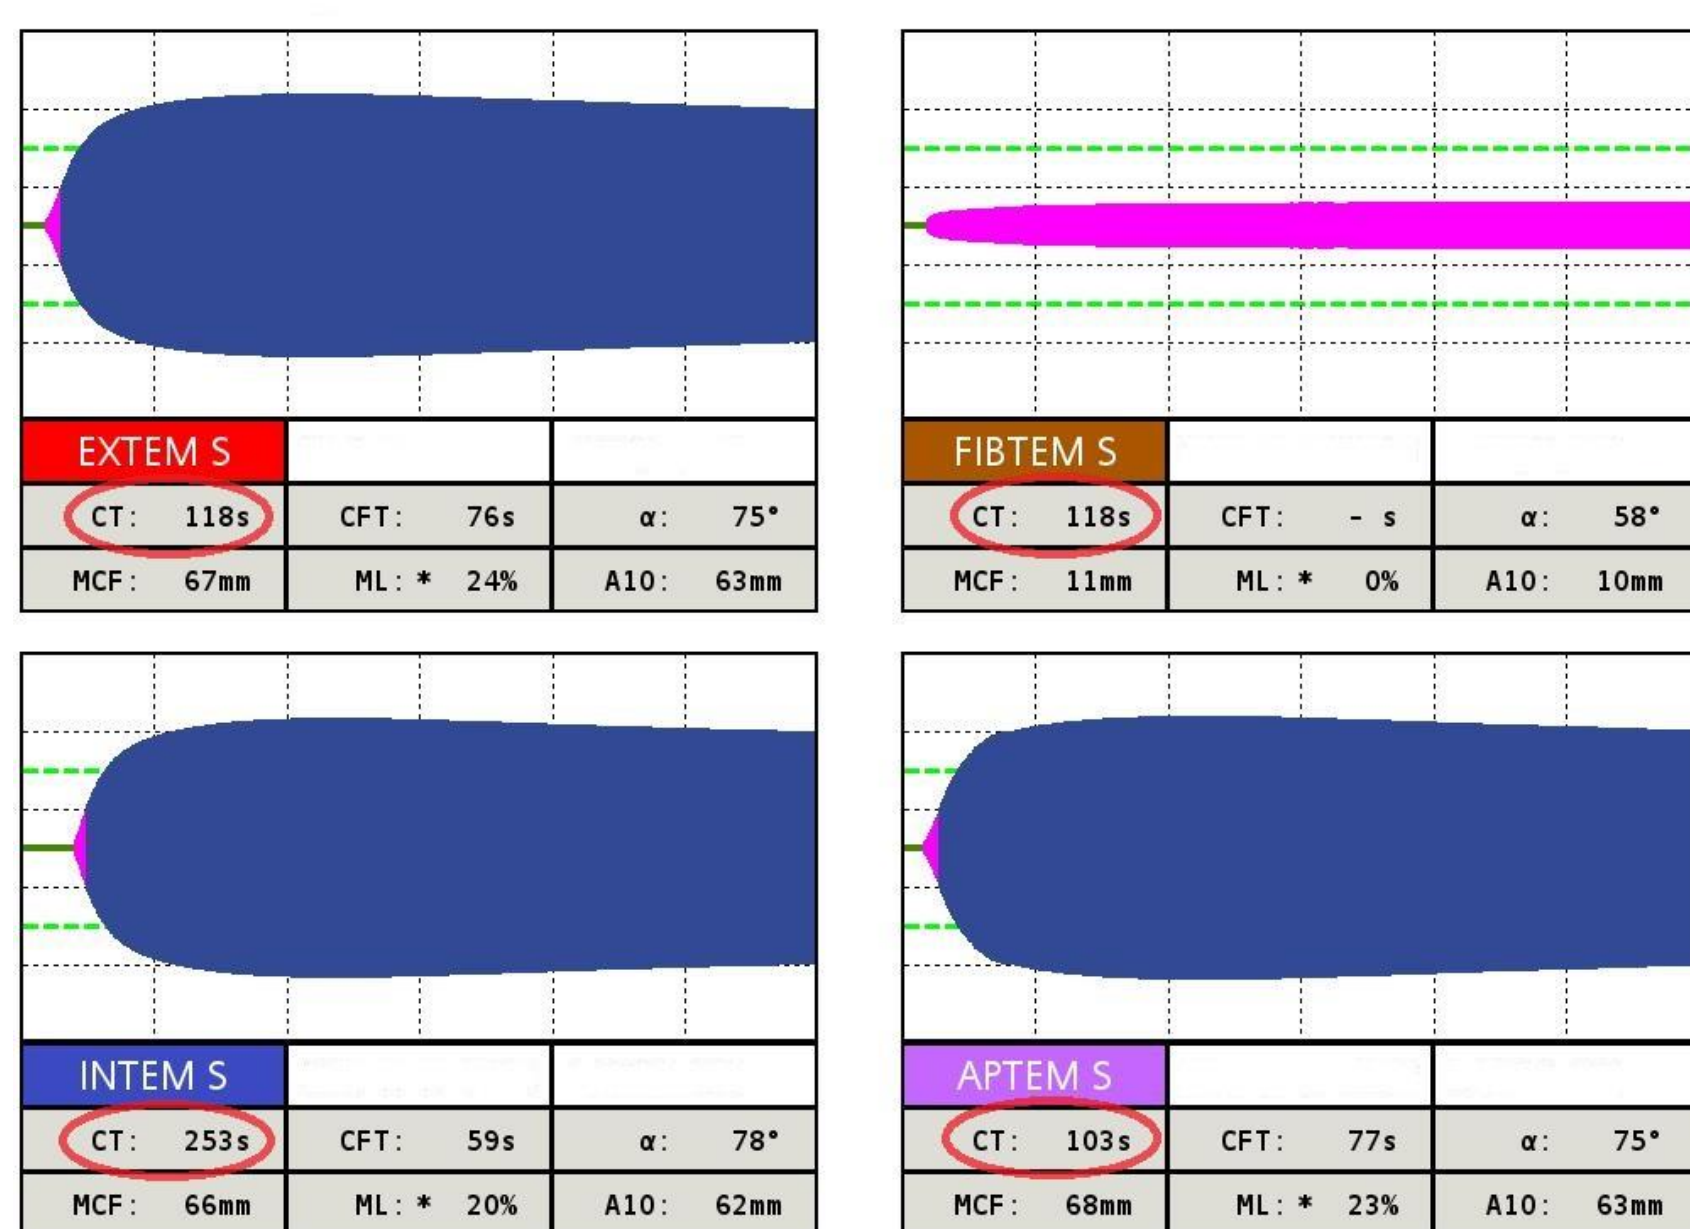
Prolonged clotting time (CT) in EXTEM, INTEM, FIBTEM and APTEM in APL-positive patient.
